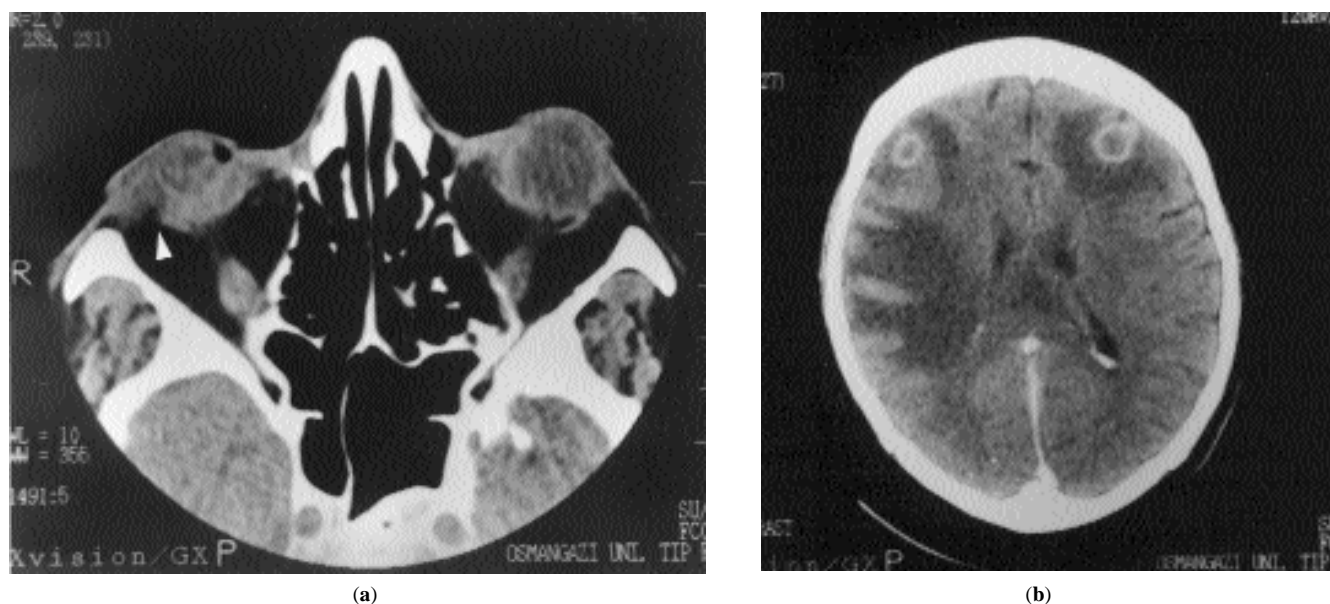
(a) An orbital computed axial tomography showing increased heterogeneous density in the vitreous of the right eye and soft tissue intensity occupying the area between the zygomatic bone and bulbous oculi (arrow). (b) A cranial computed tomography showing brain abscesses in case 1.
